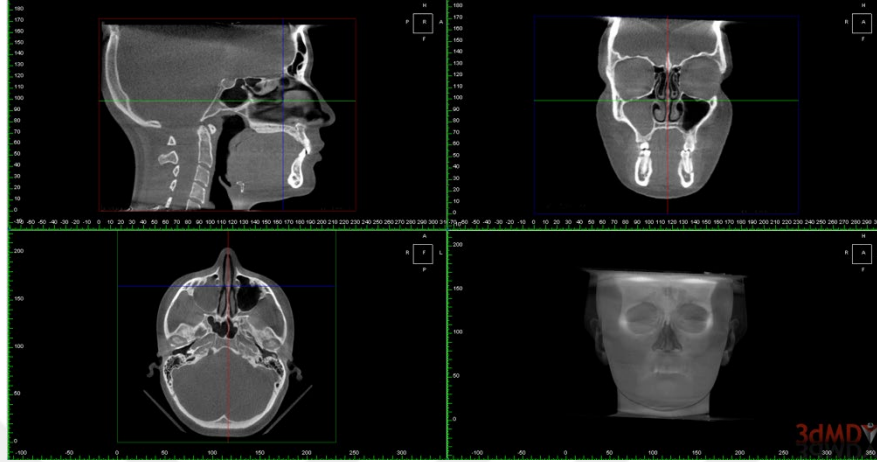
Determination of Crista Galli on CBCT
